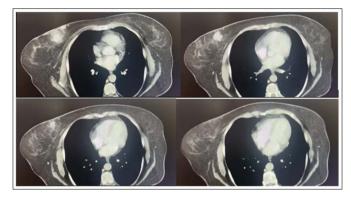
CT of the Chest with Intravenous Contrast
